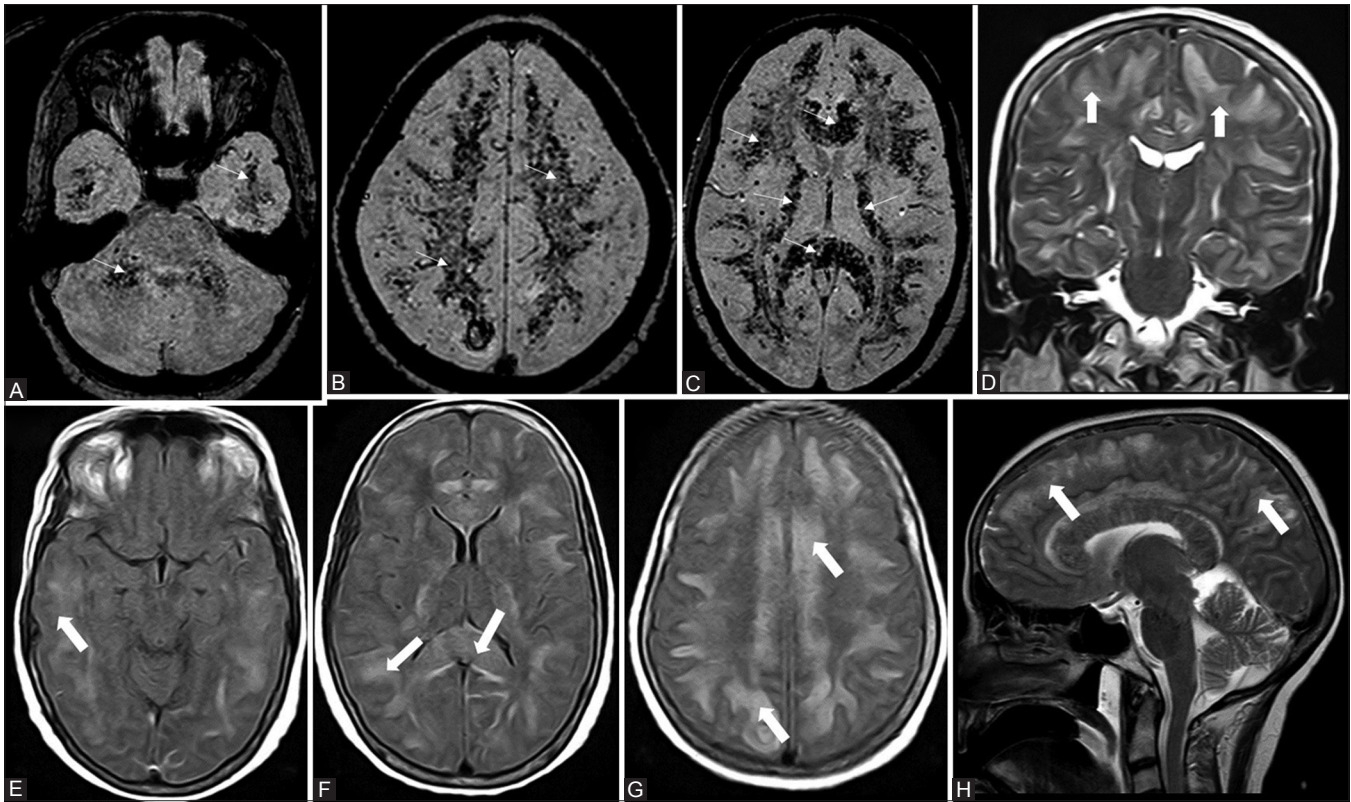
(A-H): (A-C)- Axial venobold images showing numerous foci of micro-bleeds (small arrows) blooming involving sub cortical white matter, genu-body, splenium of corpus callosum, along internal capsules, middle cerebellar peduncles. T2W coronal (D), sagittal (H), FLAIR axial images (E-G) showing diffuse areas of hyper intensities (solid arrows) suggestive of edema involving predominantly sub cortical white matter of bilateral cerebral hemispheres, corpus callosum, along internal capsules
